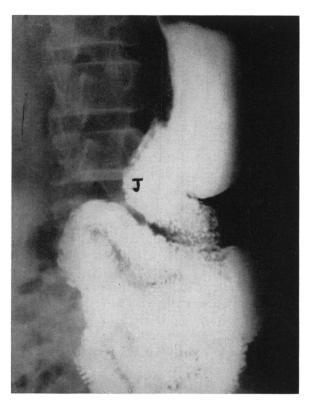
A. X-ray showing the bulging of the jejunum (J) opposite the wide anastomosis after a Polya gastrectomy.
